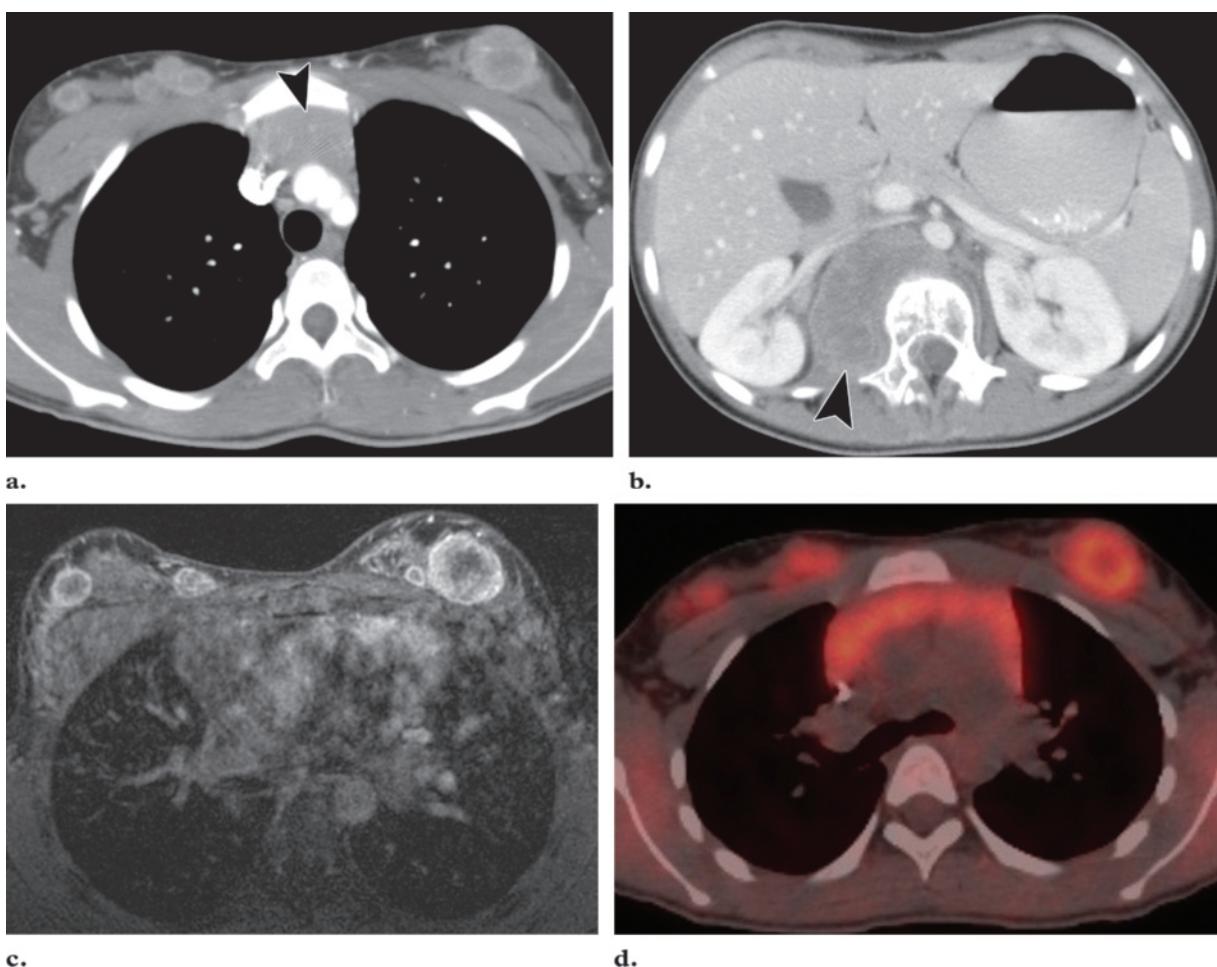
Metastatic alveolar rhabdomyosarcoma in a 14-year-old girl. (a) Axial CT scan obtained after intravenous administration of iodinated contrast material demonstrates bilateral rim-enhancing breast masses. In addition, an anterior mediastinal mass (arrowhead) is noted. (b) CT scan obtained at a lower level than a reveals a right paraspinous mass (arrowhead) with extension into the spinal canal and deviation of the spinal cord to the left. (c) T1-weighted MR image obtained after intravenous administration of gadolinium contrast material again shows the bilateral rim-enhancing breast lesions. (d) Axial fused positron emission tomographic-CT image obtained after intravenous administration of fluorine 18 fluorodeoxyglucose shows foci of abnormal metabolism in both breasts and the anterior mediastinum.
